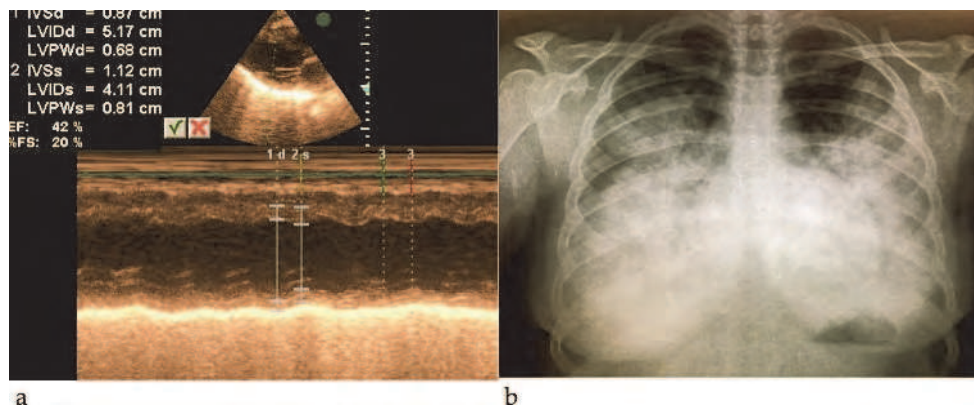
M-mode echocardiography (a) and chest x-ray (b) of an adolescent girl with presumed viral myocarditis. M-mode echocardiography demonstrating systolic dysfunction with flattened interventricular septum. In chest radiography, there was prominent diffuse vascular congestion that is compatible with pulmonary edema. 13 year old girl admitted our hospital with dyspnea and tachycardia. She had a history of preceding viral upper respiratory infection. The patient intubated and connected to mechanical ventilation on day one of emergency room admission. She died within 72 hours after initial presentation.
